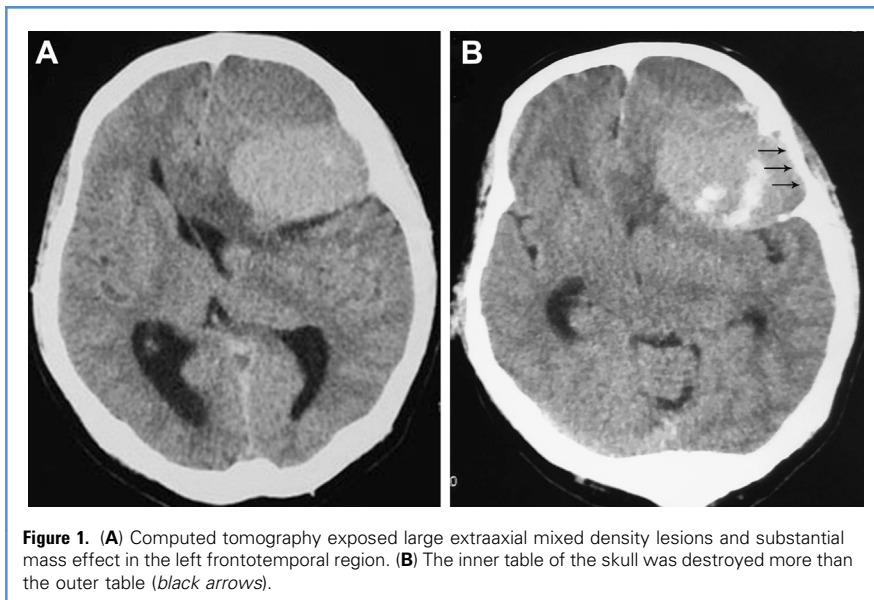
(A) Computed tomography exposed large extraaxial mixed density lesions and substantial mass effect in the left frontotemporal region. (B) The inner table of the skull was destroyed more than the outer table (black arrows).
